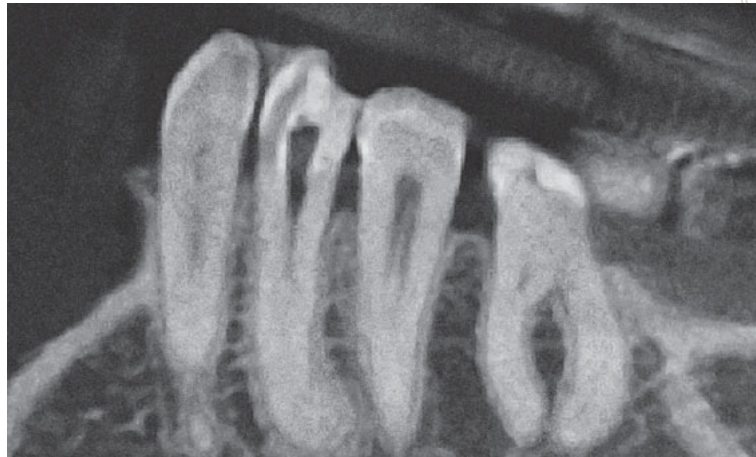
CBCT image showing the presence of a canal in a coronal section of tooth 34. The canal starts from the coronal third of the root and divides at the level of the middle third into two canals – one buccal and one lingual – thus continuing to the root apex.
